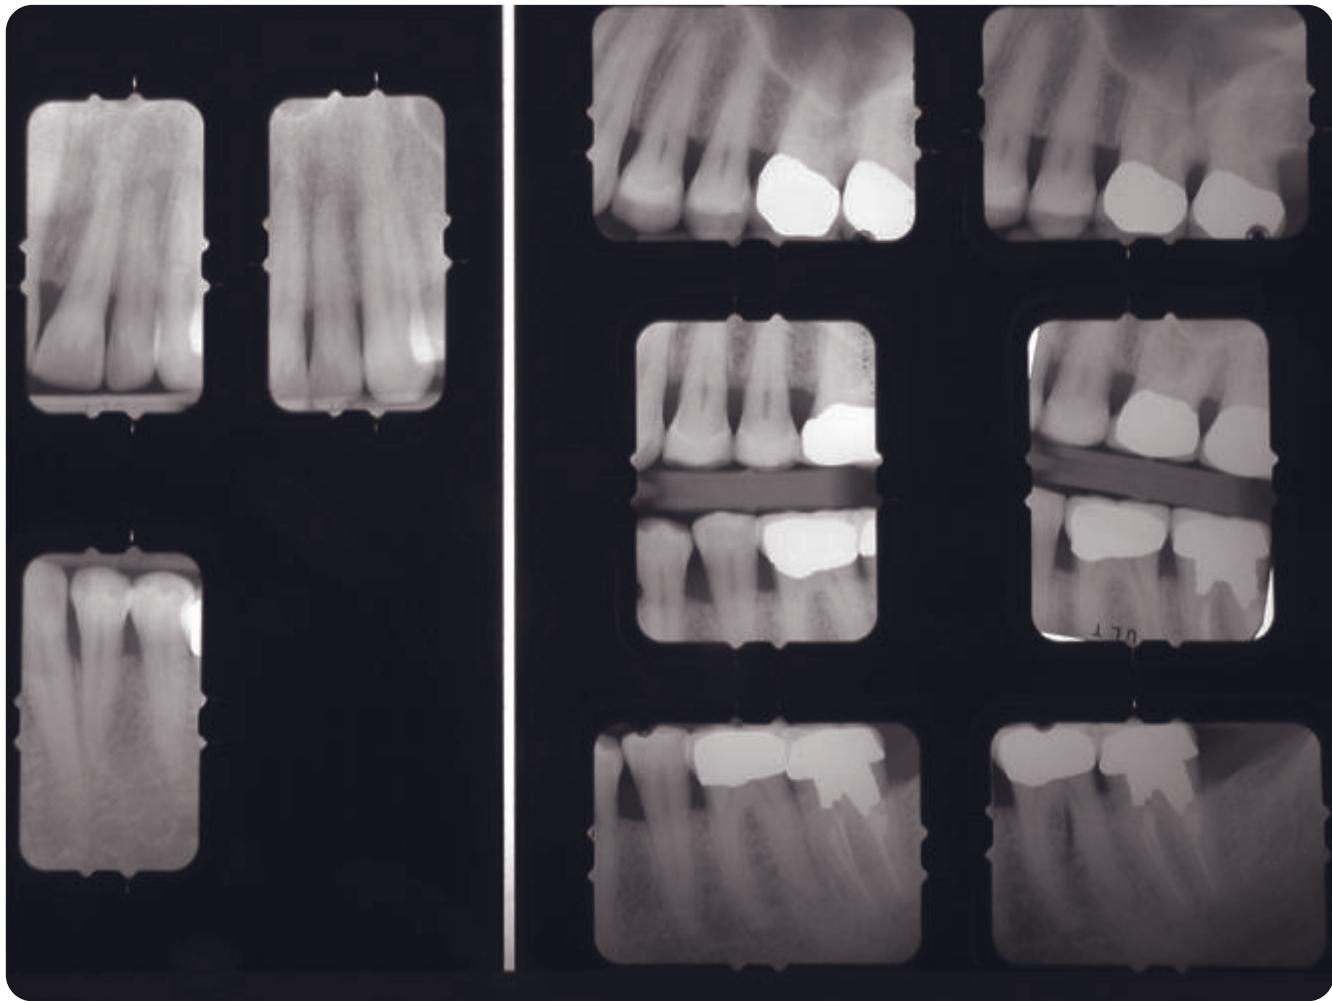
Posttreatment radiographs of the completed restoration, left side. Despite the occlusal reduction that was necessary on all molars to gain an occlusion that was in harmony with adapted centric posture, none of the teeth required endodontic therapy.
